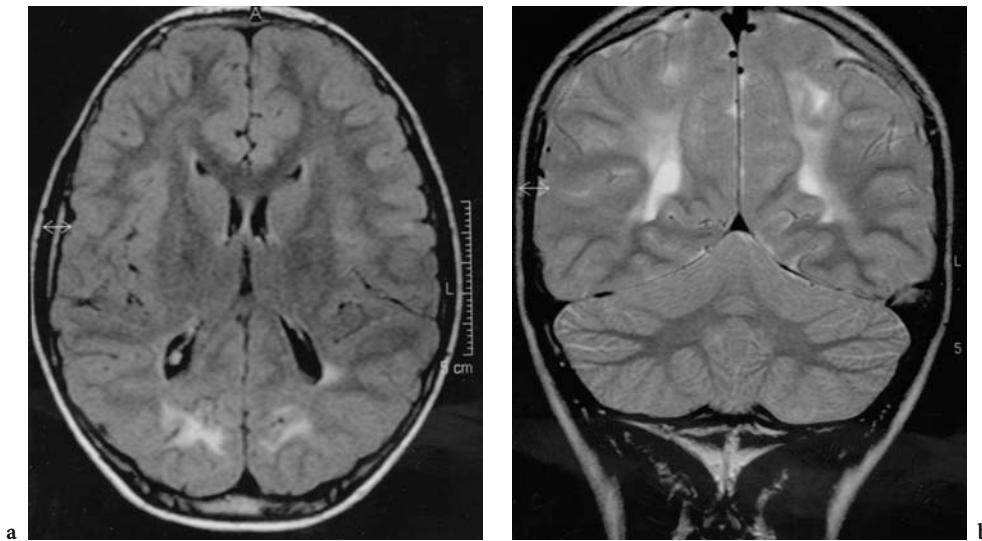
a Axial, b coronal T2-weighted FSE MRI (mod.) of a 10-year-old boy with several convulsions of recent onset. T2 hyperintensity of bilateral occipital white matter. No clinical/ophthalmological correlate. Normal mitochondrial and peroxisomal laboratory findings
